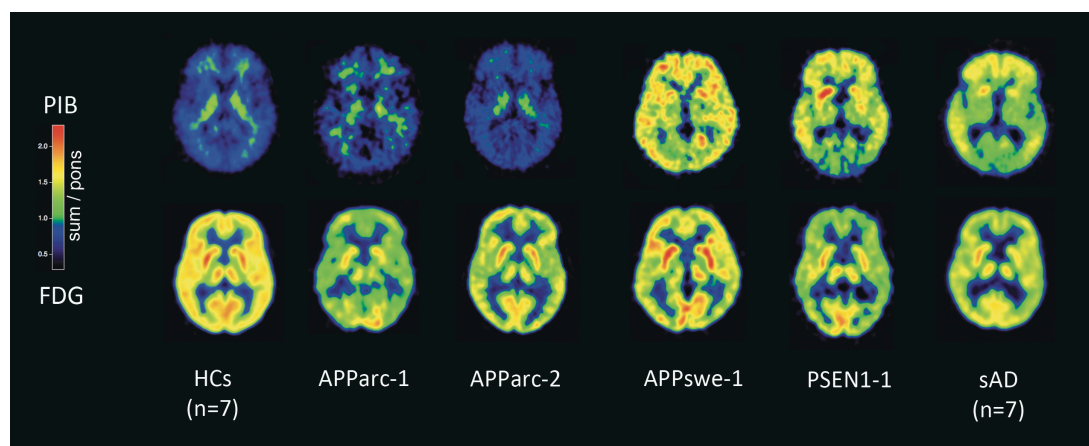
PIB and FDG PET scans of seven healthy controls, the two carriers of the *APP*_{arc} mutation, one *PSEN1* H163Y mutation carrier, one *APP*_{swe} mutation carrier, and seven sAD patients. Of note is the lack of PIB retention in the *APP*_{arc} mutation carriers. HCs: Healthy controls; sAD: Sporadic AD.
